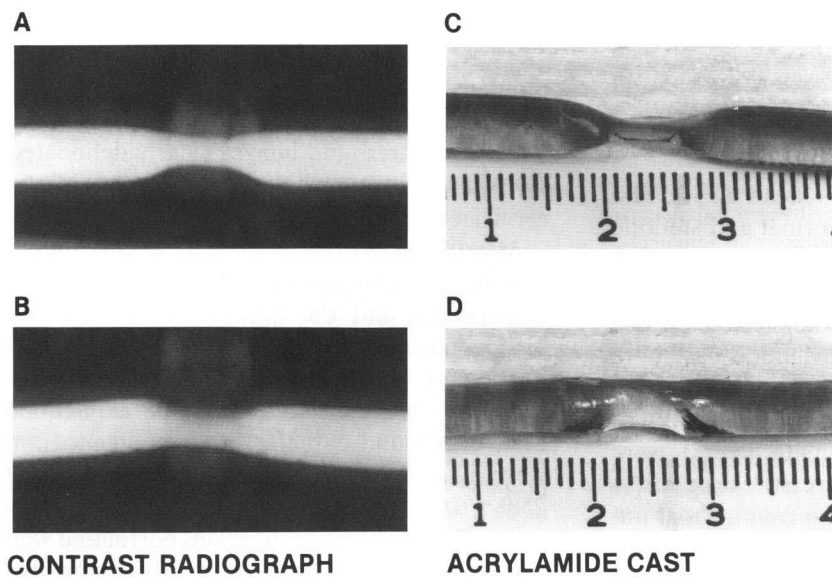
Contrast radiographs of a stenotic plastic tube in orthogonal projections compared with the acrylicamide cast made from the same stenotic tube.
